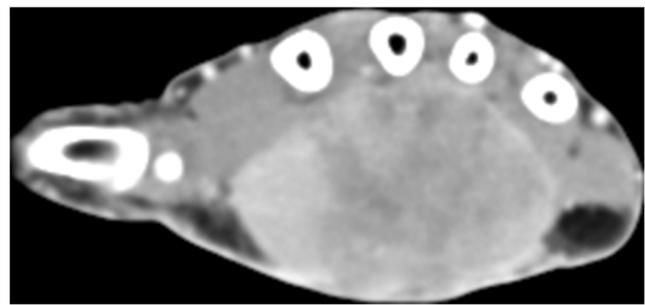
Contrast-enhanced computed tomography showing a lobulated tumor measuring $5.2 \times 5.0 \times 3.5$ cm, with relatively distinct boundaries and heterogeneous enhancement
